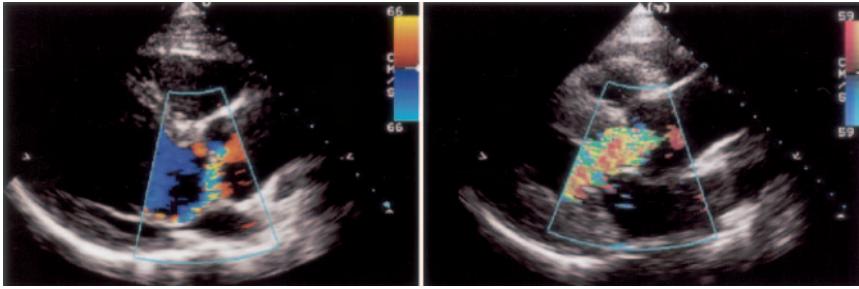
Color flow images from parasternal long-axis views in patients with mild (left) and severe (right) AR. Jet width is $<25\%$ of LVOT width in mild AR. This jet is eccentric; width is measured at the origin of the jet adjacent to the leaflets. In severe AR, jet width is usually $>50\%$ of LVOT width. A jet width/LVOT width $>65\%$ (as in this patient) is specific for severe AR.³⁹
